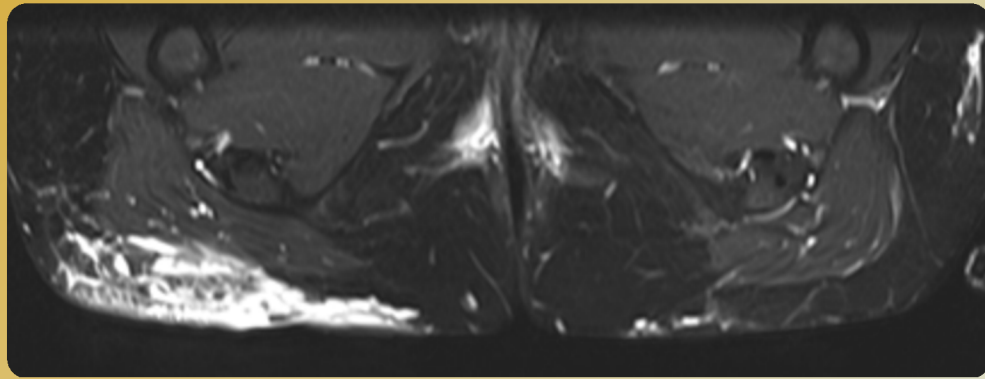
subcutaneous infiltration of the right gluteal region, with the presence of a deep fusiform intramuscular collection on MRI.
